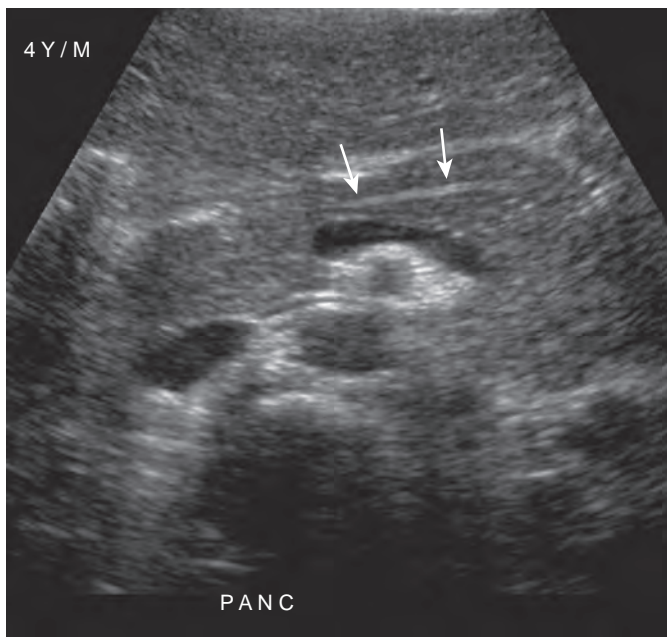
Normal pancreatic duct. The transverse sonographic image of the pancreas demonstrates parallel echogenic lines in the body of the pancreas consistent with a normal pancreatic duct (arrows).
